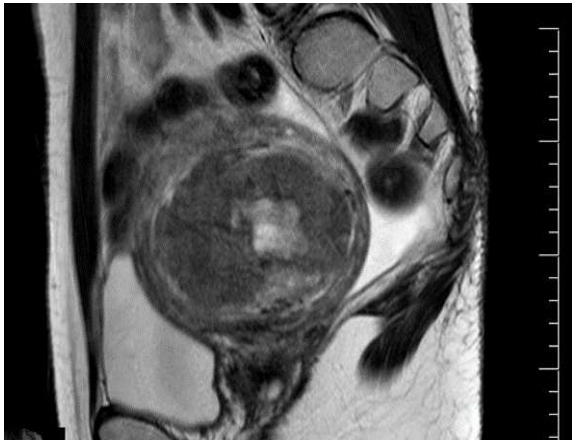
Pelvic MRI (T2-weighted imaging): On T2-weighted imaging, a low-intensity area with a maximum diameter of 80 mm and clear boundary was present on the posterior uterine wall.
